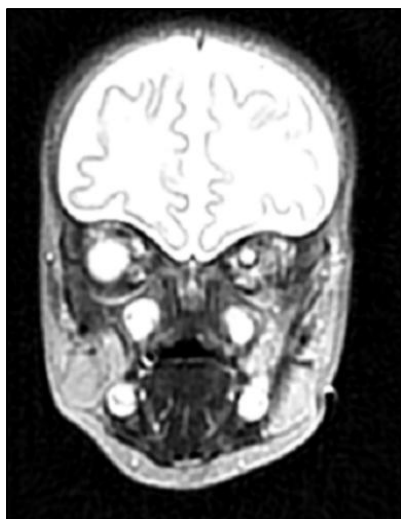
MRI showing absent nasal cavities.
